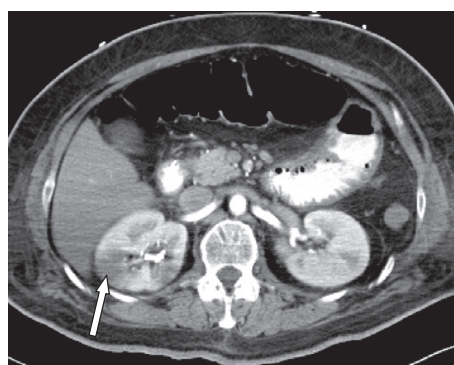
Nephrographic phase contrast enhanced CT scan shows right renal wedge shaped cortical infarct (arrow).
